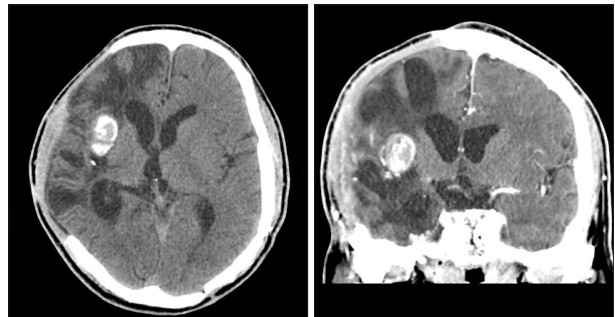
Axial and coronal CT scans taken 2 years after admission show remained calcified brain abscess.
